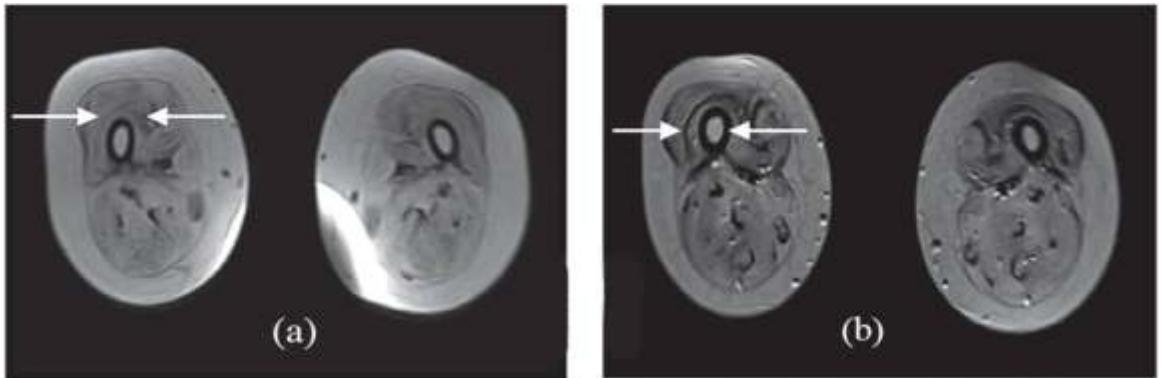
Figures a & b shows the Musculoskeletal MRI images before and after stem cell therapy, respectively. Figure b shows regeneration of muscle in vastus medialis and vastus lateralis.
